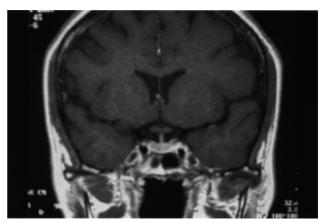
Magnetic resonance imaging seven years after the beginning of treatment discloses a normal pituitary image.
